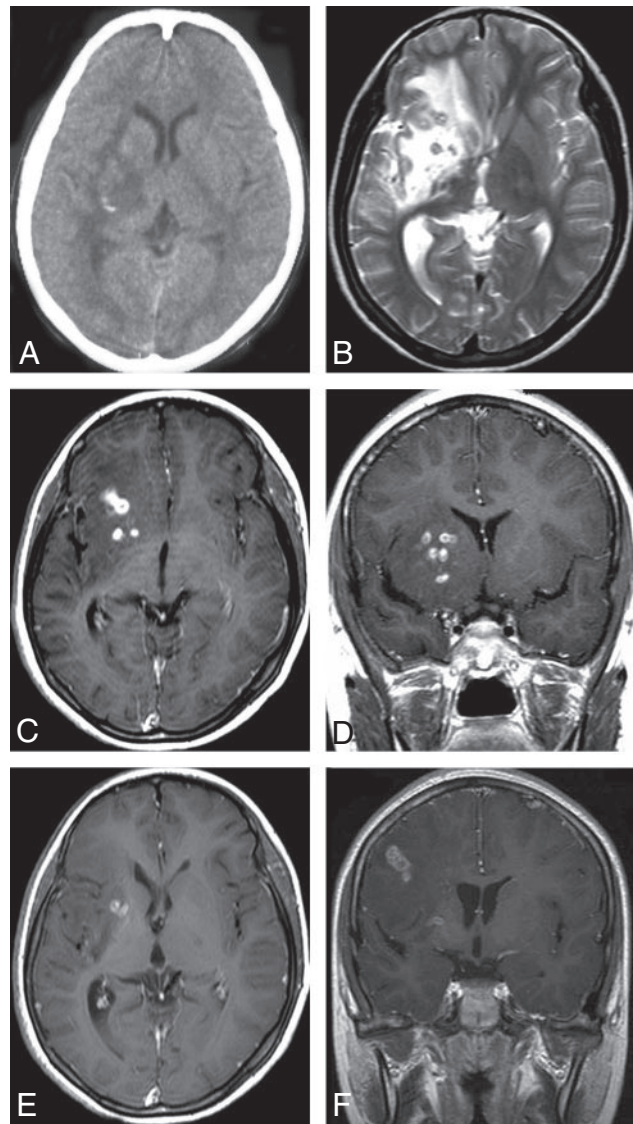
Case 6. Images of the brain of a 14-year-old boy with a 4-year history of seizures and left hemiparesis. *A*, Precontrast CT scan shows an extensive area of low attenuation in the right basal ganglia with a punctate calcification centrally. *B*, Axial T2-weighted image of the same section as the CT image in (*A*) shows hyperintense area in the right basal ganglia. However, calcification seen on CT image cannot be shown clearly on MR image. *C–D*, Postcontrast axial (*C*) and coronal (*D*) T1-weighted images show bead-shaped enhancement in the right basal ganglia. *E–F*, After 4 months, postcontrast axial (*E*) and coronal (*F*) T1-weighted images of the same patient show the tunnel-shaped enhancement in the right parietal lobe with small amounts of residual bead-shaped enhancement in the right basal ganglia, representing the migration of the worm and lesions shifting from the right basal ganglia to the right parietal lobe. Preoperative ELISA on serum and on CSF revealed strongly positive against *Spirometra mansoni*. A live worm was found at craniotomy.
